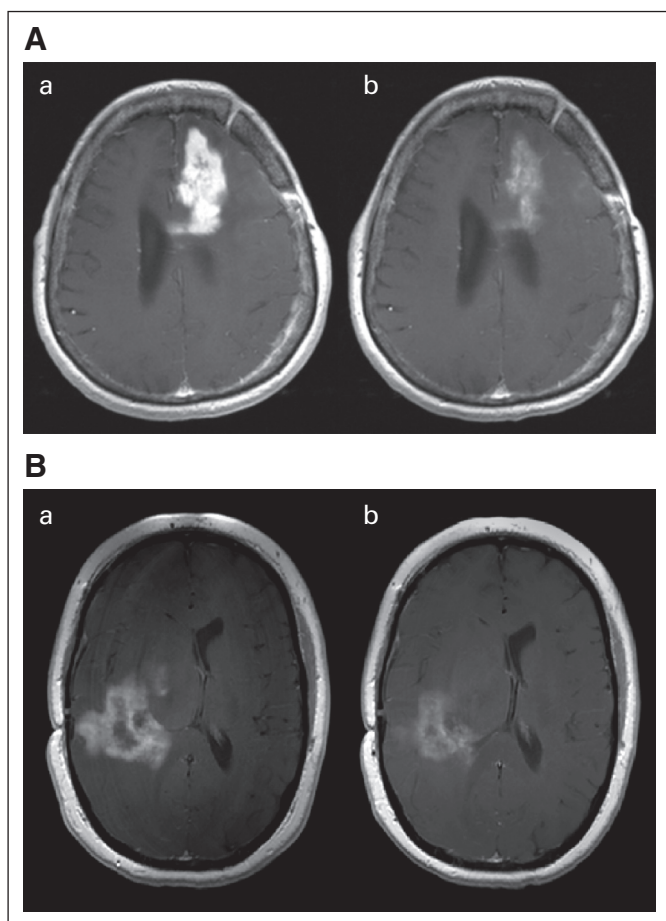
(A) Pseudoresponse. Axial T1-weighted contrast enhanced MRI of left frontal recurrent glioblastoma a) before and b) one day after therapy with cediranib (pan-VEGFR inhibitor) showing significant reduction in contrast enhancement. The reduction in contrast enhancement within 1 day of therapy is more likely to be caused by reduced vascular permeability to contrast than to a true antitumor effect. (Slide courtesy of A. Gregory Sorensen, Massachusetts General Hospital; Adapted with permission from Batchelor et al. *Cancer Cell* 11:83-95, 2007⁴³). (B) Pseudoresponse. Axial T1-weighted contrast enhanced MRI of right parietal glioblastoma a) before and b) 1 day after therapy with XL184 (vascular endothelial growth factor receptor [VEGFR] and MET inhibitor) showing significant reduction in contrast enhancement. (Slide courtesy of A. Gregory Sorensen, Massachusetts General Hospital).
